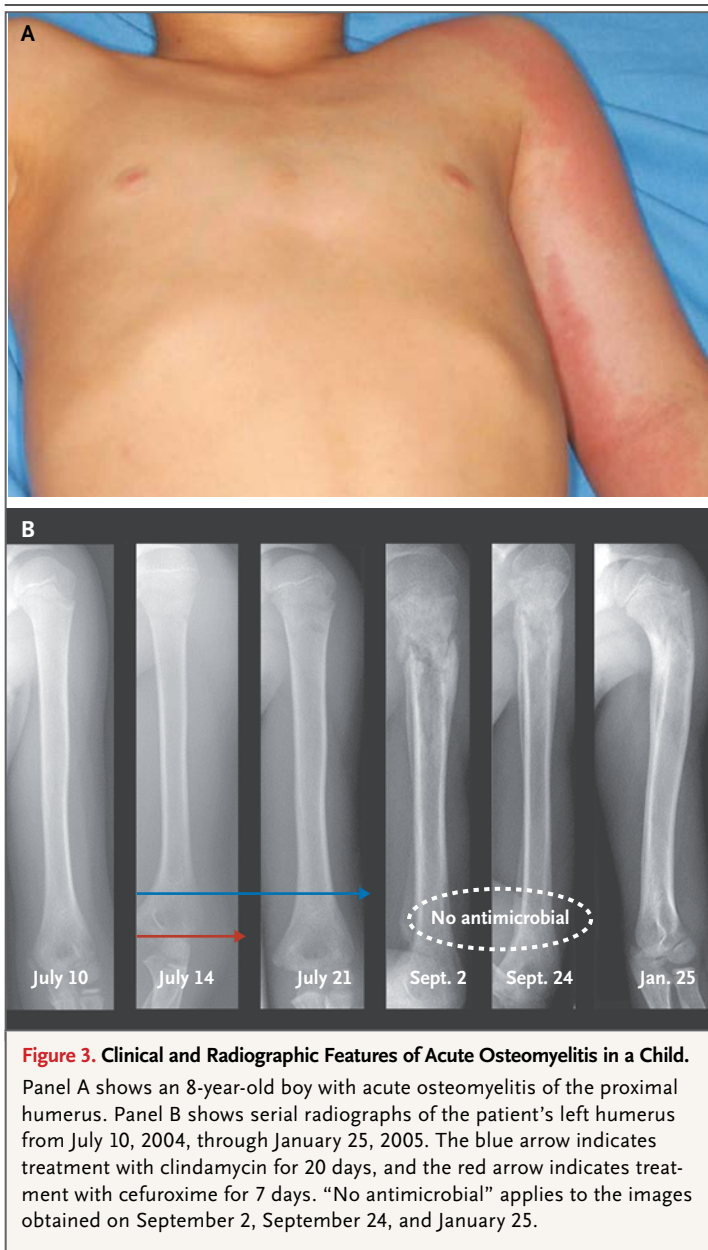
Clinical and Radiographic Features of Acute Osteomyelitis in a Child.
